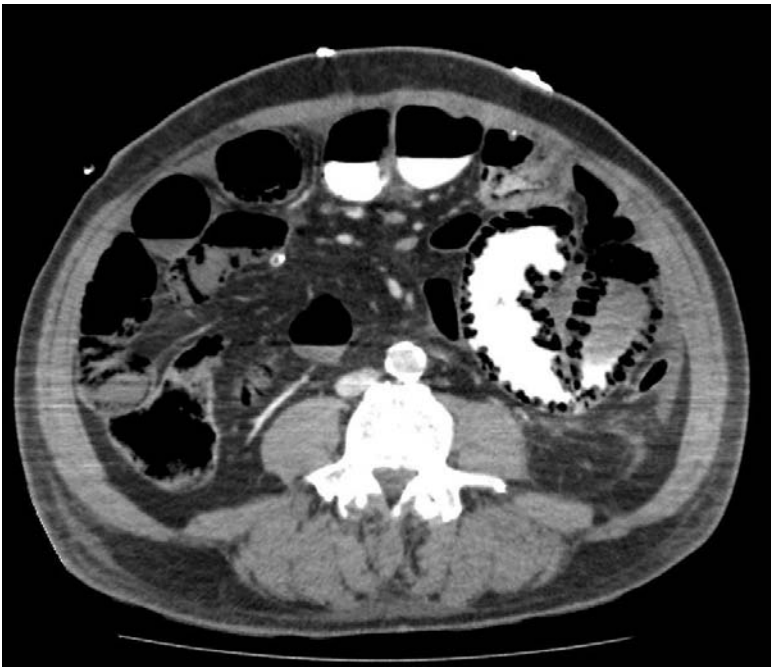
Axial abdominal CT showing Intramural bowel gas or pneumatosis intestinalis[65]
